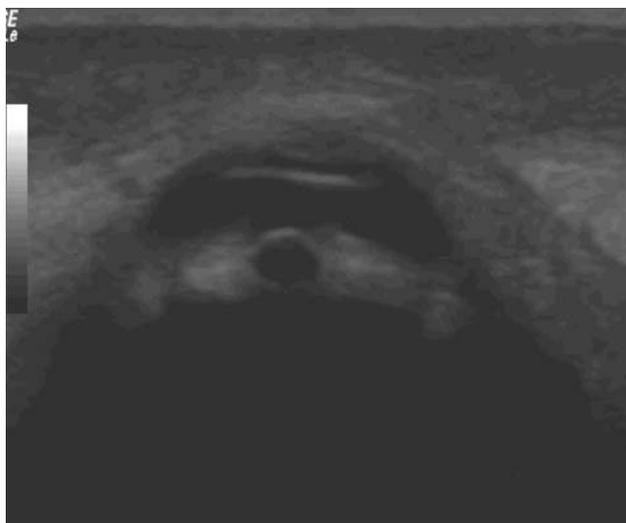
Coronal image of the iris and pupil visualized with ultrasound in B-mode settings on the patient in the case study
